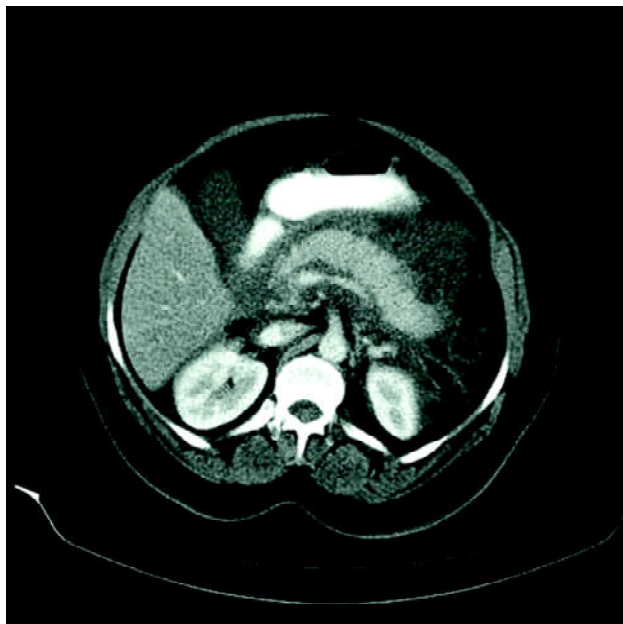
Abdominal CT showing features of acute pancreatitis.
